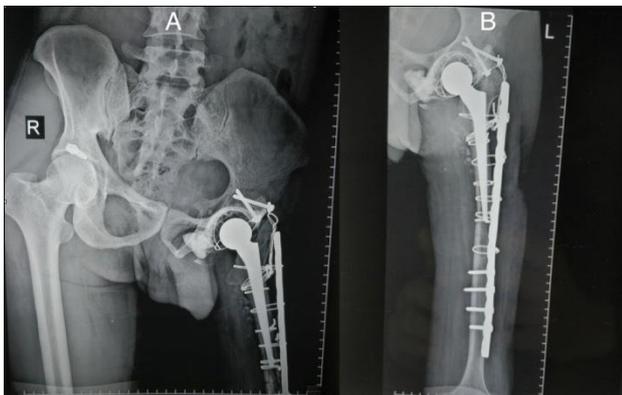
Postoperative radiographs at one year follow up. A: pelvis with both hips. B: full length femur.
